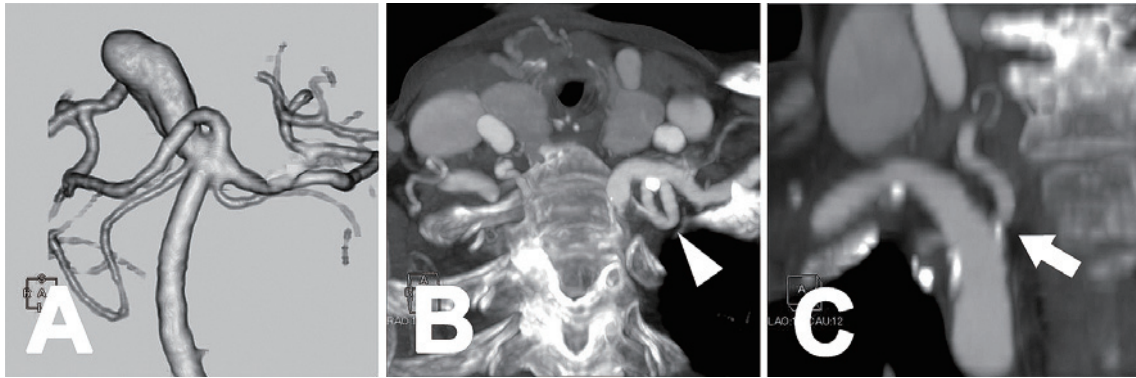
Computed tomography angiography showing a partially thrombosed right basilar artery-superior cerebellar artery aneurysm (A); strong tortuosity in the proximal left vertebral artery (B, arrowhead) and stenosis at the origin of the right vertebral artery (C, arrow) are noted.
